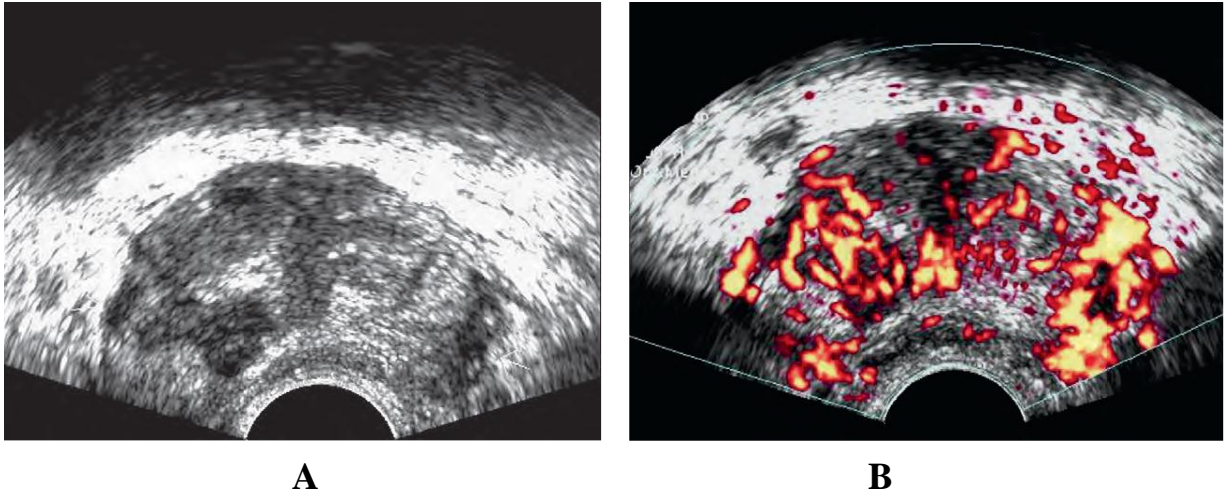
shows prostatitis A, Biopsy-proven non acute inflammation. Multiple geographic hypoechoic areas on both sides B, Power Doppler ultrasound demonstrates increased vascularity in area of inflammation.
